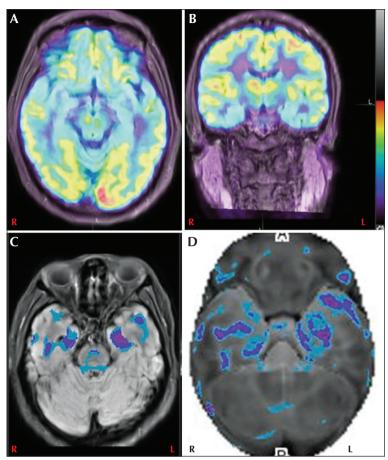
Axial (A) and coronal (B) fused PET MRI showing bitemporal (left>right) hypometabolism. Axial fused PET MRI (C) and surface rendering (D) in the same patient shows significant clustering in the bitemporal lobes (left>right). L: left; R: right.
